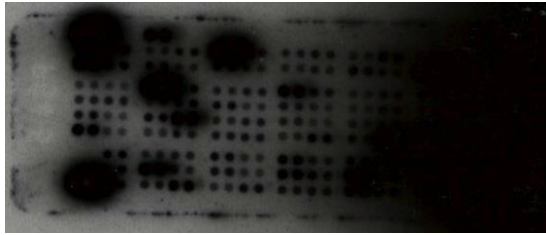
X-ray of protein array membrane incubated with CVF 1 in 100 dilution
